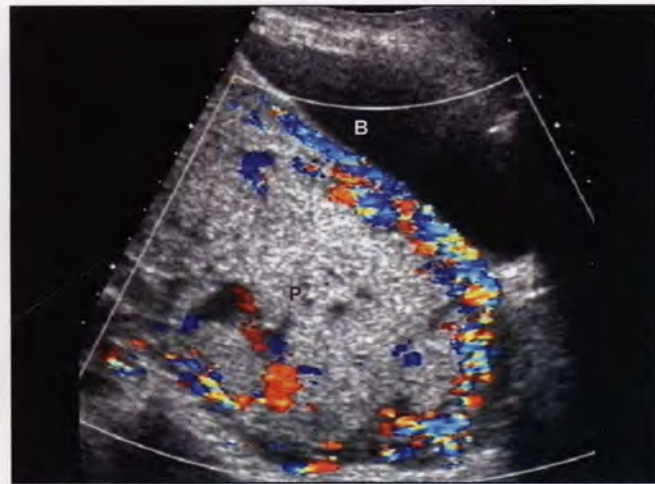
Color Doppler scanning at 27 weeks' gestation in a case of placenta percreta demonstrating prominent placental vessels extending across the myometrium into the bladder wall (B: Bladder; P: Placenta)
